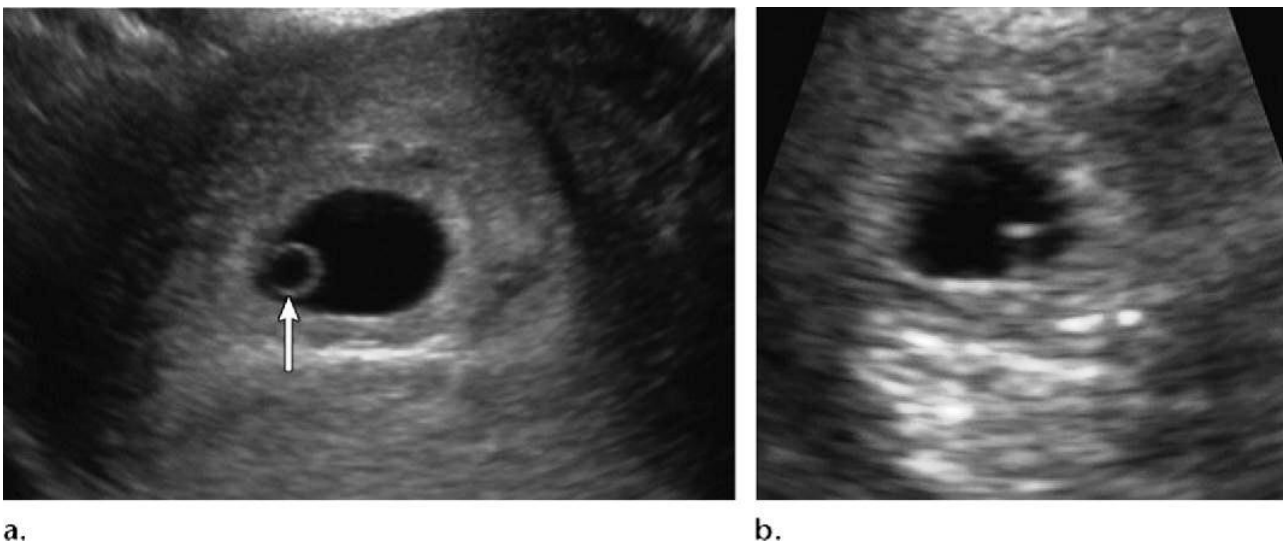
The endovaginal ultrasound scans taken during the early stages of pregnancy, all showed a healthy yolk sac (YS). (a) The echogenic ring that makes up the yolk sac can be seen as an eccentric circular structure within the gestational sac. The mean square deviation is twelve millimeters, which indicates that the gestational age is 5 weeks and six days. (b) The YS is shown as 2 parallel lines within a smaller gestational sac. These lines depict the leading edge as well as the rear wall of the sac. The mean square deviation is four millimeters, which indicates that the gestational age is five weeks and 0 days (11).
